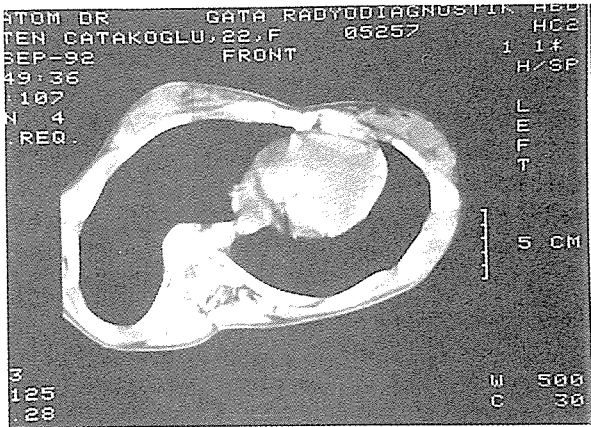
A.Ç. 22 Yr. female, Preop. CT
